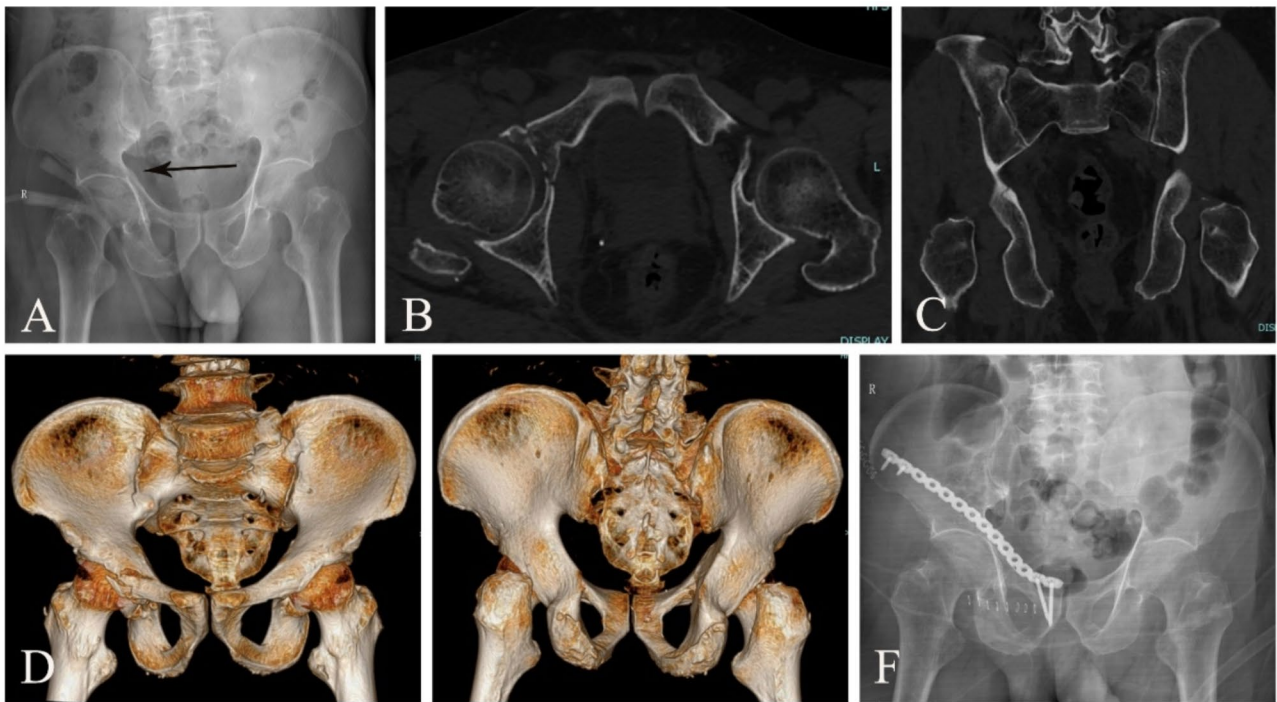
An elderly male patient with right superior and inferior ramus of the pubis, acetabular anterior column, and left sacroiliac joint injuries sustained from a motor collision was surgically treated via the left MIPPO approach. A-E: (A) Presurgical AP radiograph, (B) axial view, (C) coronal view, and (D, E) three-dimensional CT reconstruction showed separation and displacement of the fracture fragment. F: Postoperative AP radiograph demonstrated satisfactory restoration of the fracture
